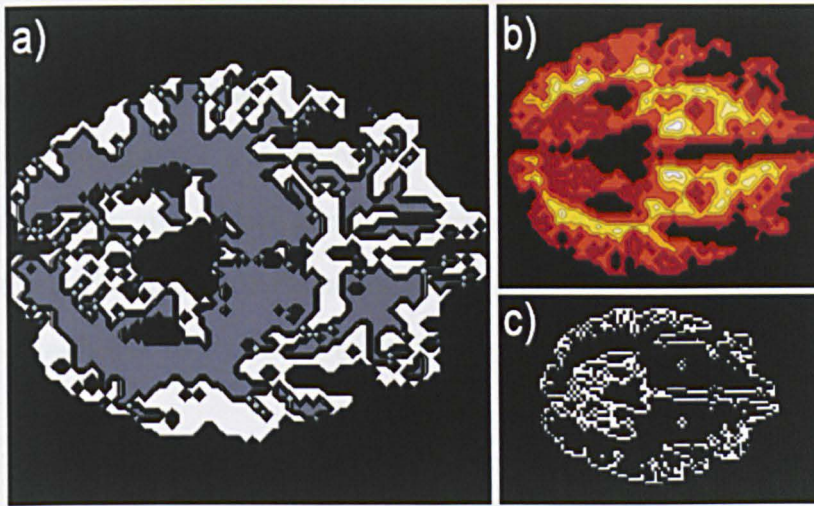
Here details of the MRI data used in the arterial tree generation model are displayed. Panel a) shows the segmented brain tissue. b) shows the result of the distance function calculation of the brain surface, which is shown in panel c).
